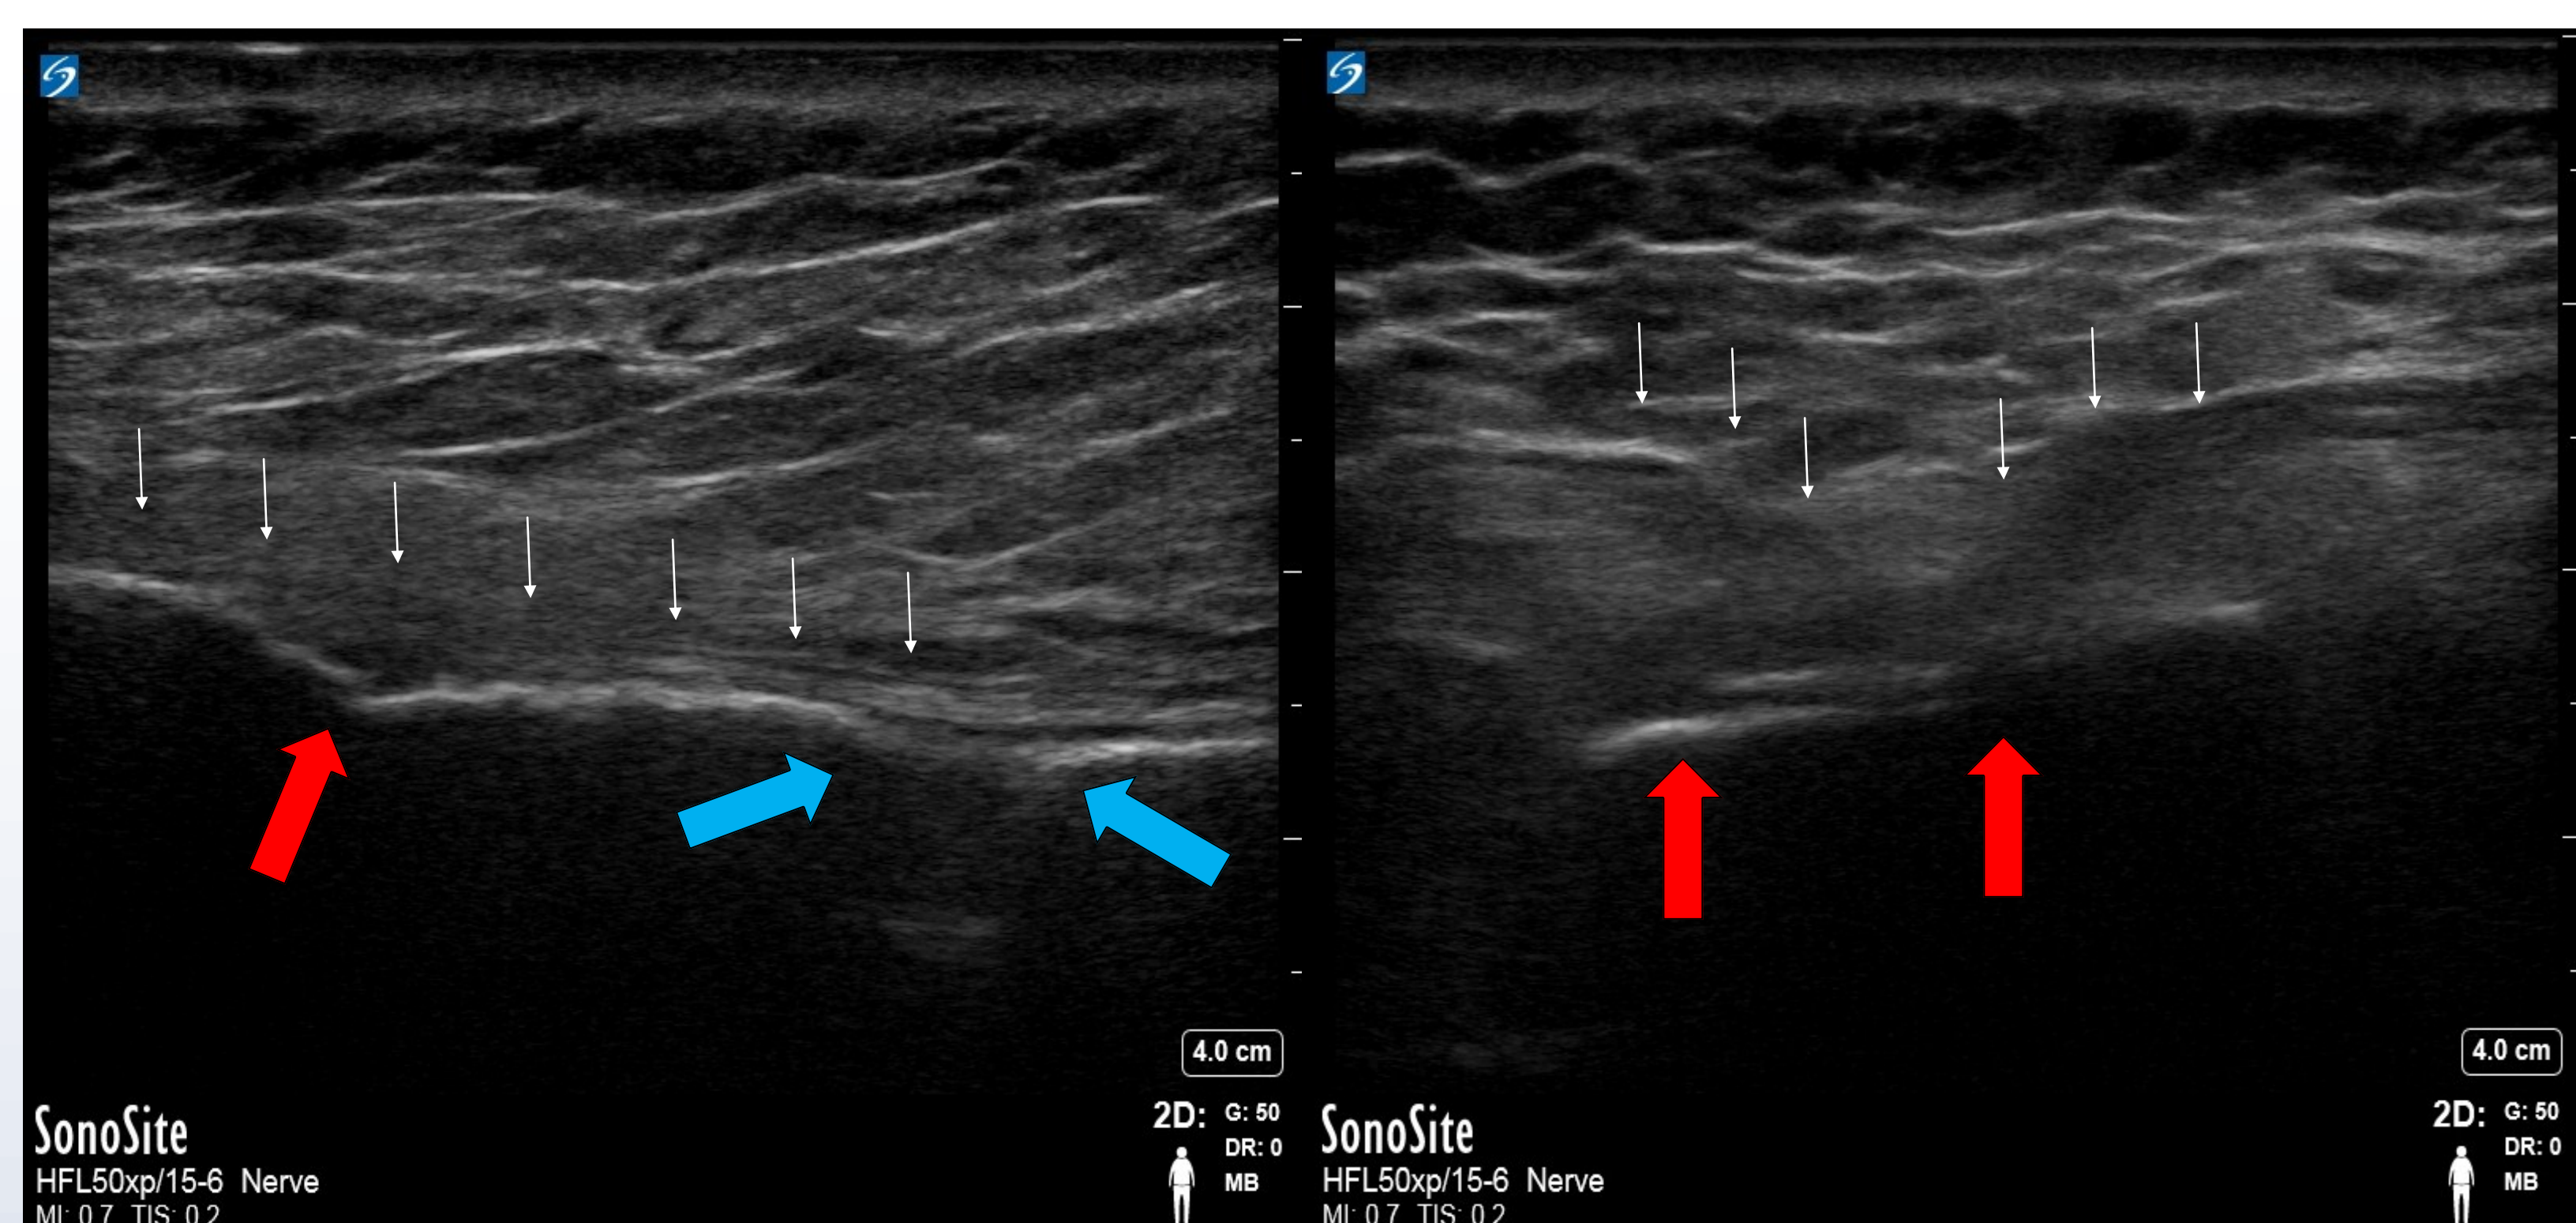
Longitudinal ultrasound of the sternum demonstrating the fracture (red arrows), an incidental finding of a sternal foramen (blue arrows) and the periosteal catheter (white arrows).
